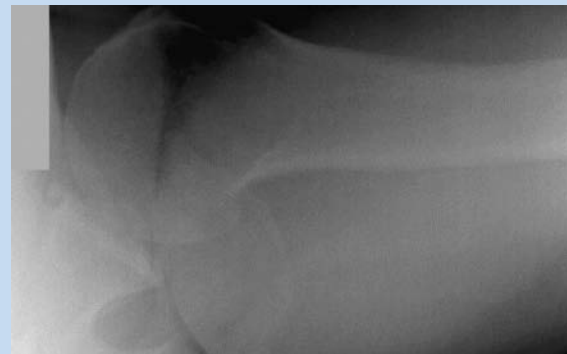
West Point axillary view. With the patient made prone, and the upper arm is abducted 90° from the trunk while the hand is pronated. A radiographic beam is directed at the axilla at a 25° angle medially and 25° angle cephalad, centered inferiorly and medially to the acromioclavicular joint.
